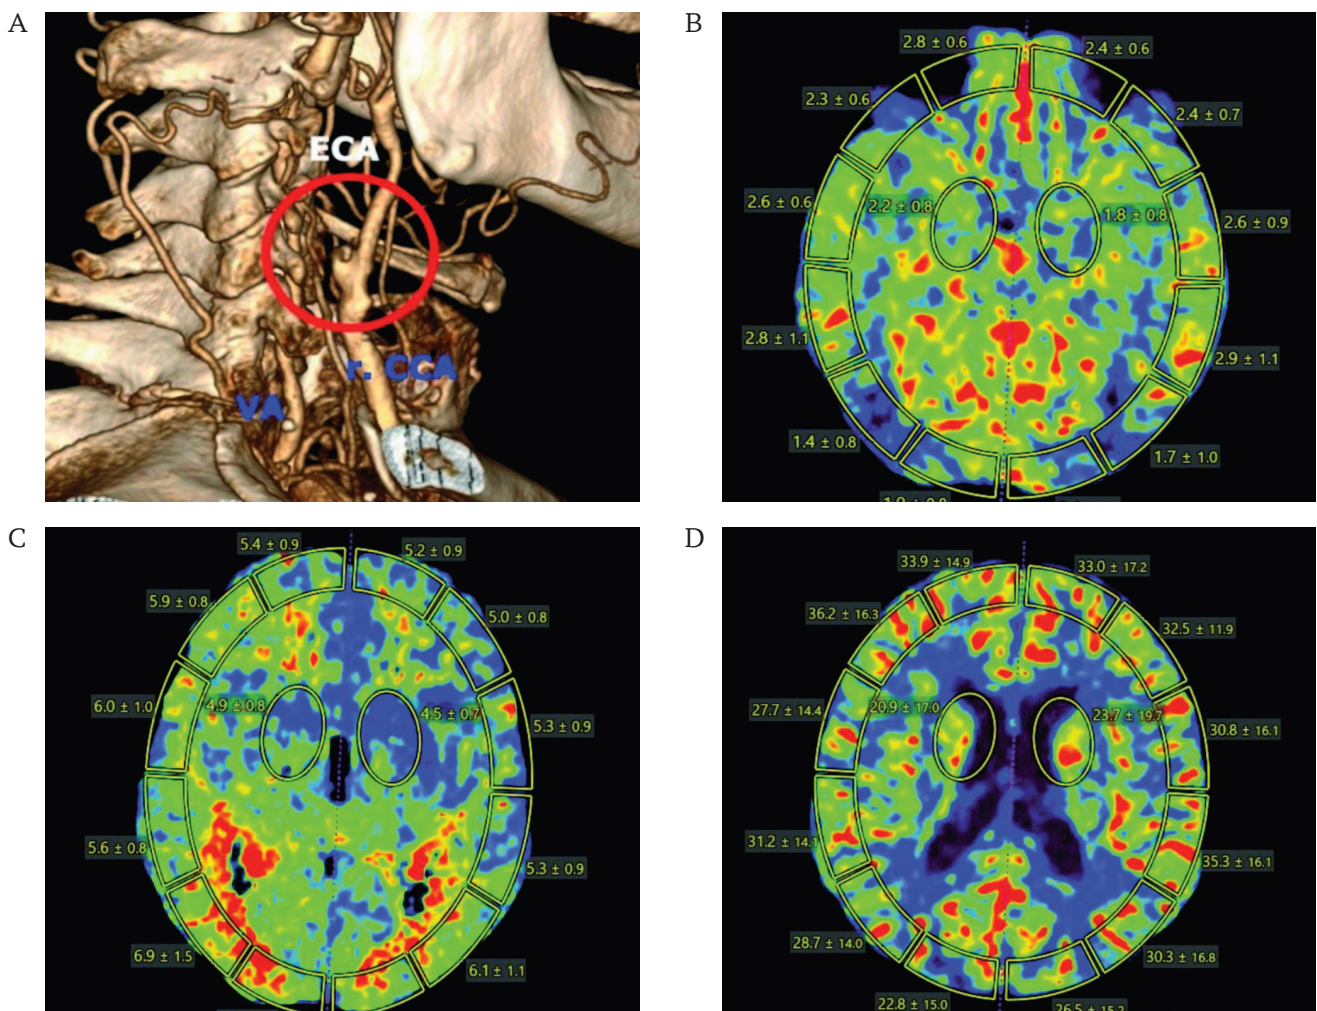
Computed tomography angiography of the brachiocephalic and cerebral arteries, February 5, 2025 (A), brain computed tomography perfusion, February 6, 2025 (B, C, D) before surgery.
